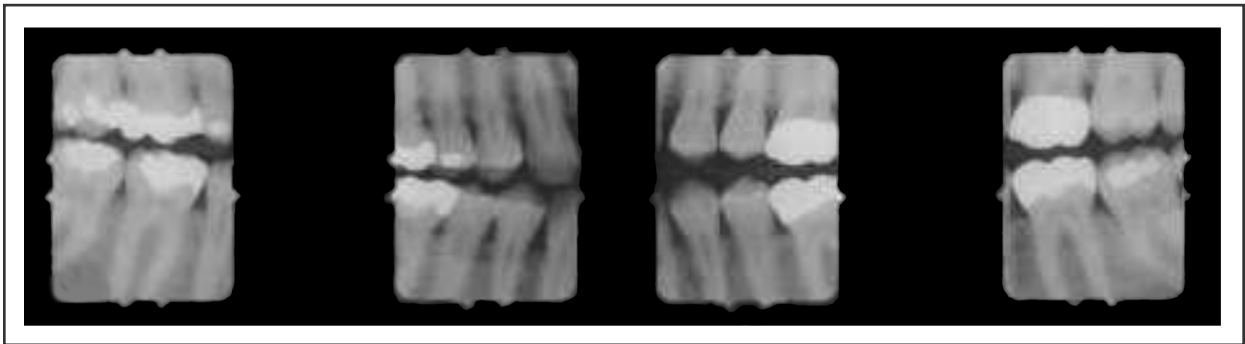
Bitewing radiographs¹²
